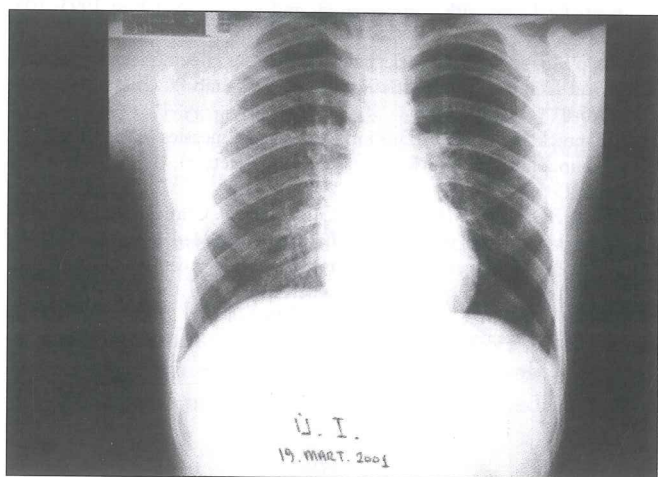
Chest x-ray on day 12 was completely normal.
